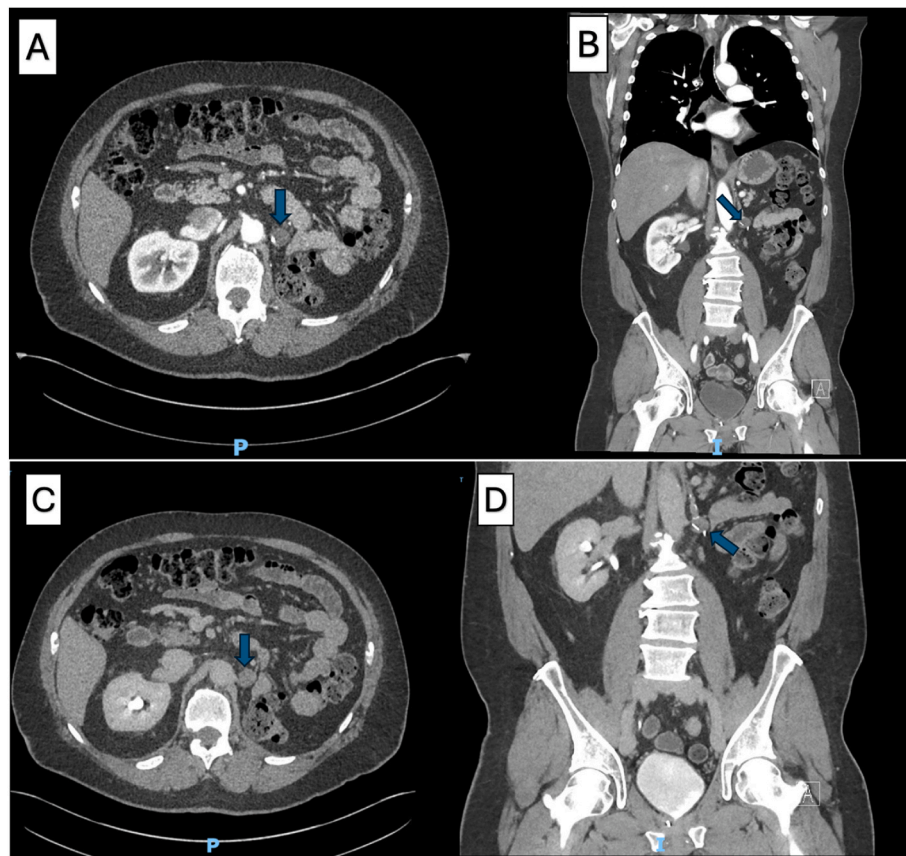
Figure 1. Axial (B) and coronal (B) arterial-phase computed tomography (CT) images show a mildly enhancing soft tissue nodule. Delayed-phase axial (C) and coronal (D) CT images show a hyperdense mass at the nephrectomy surgical site.
